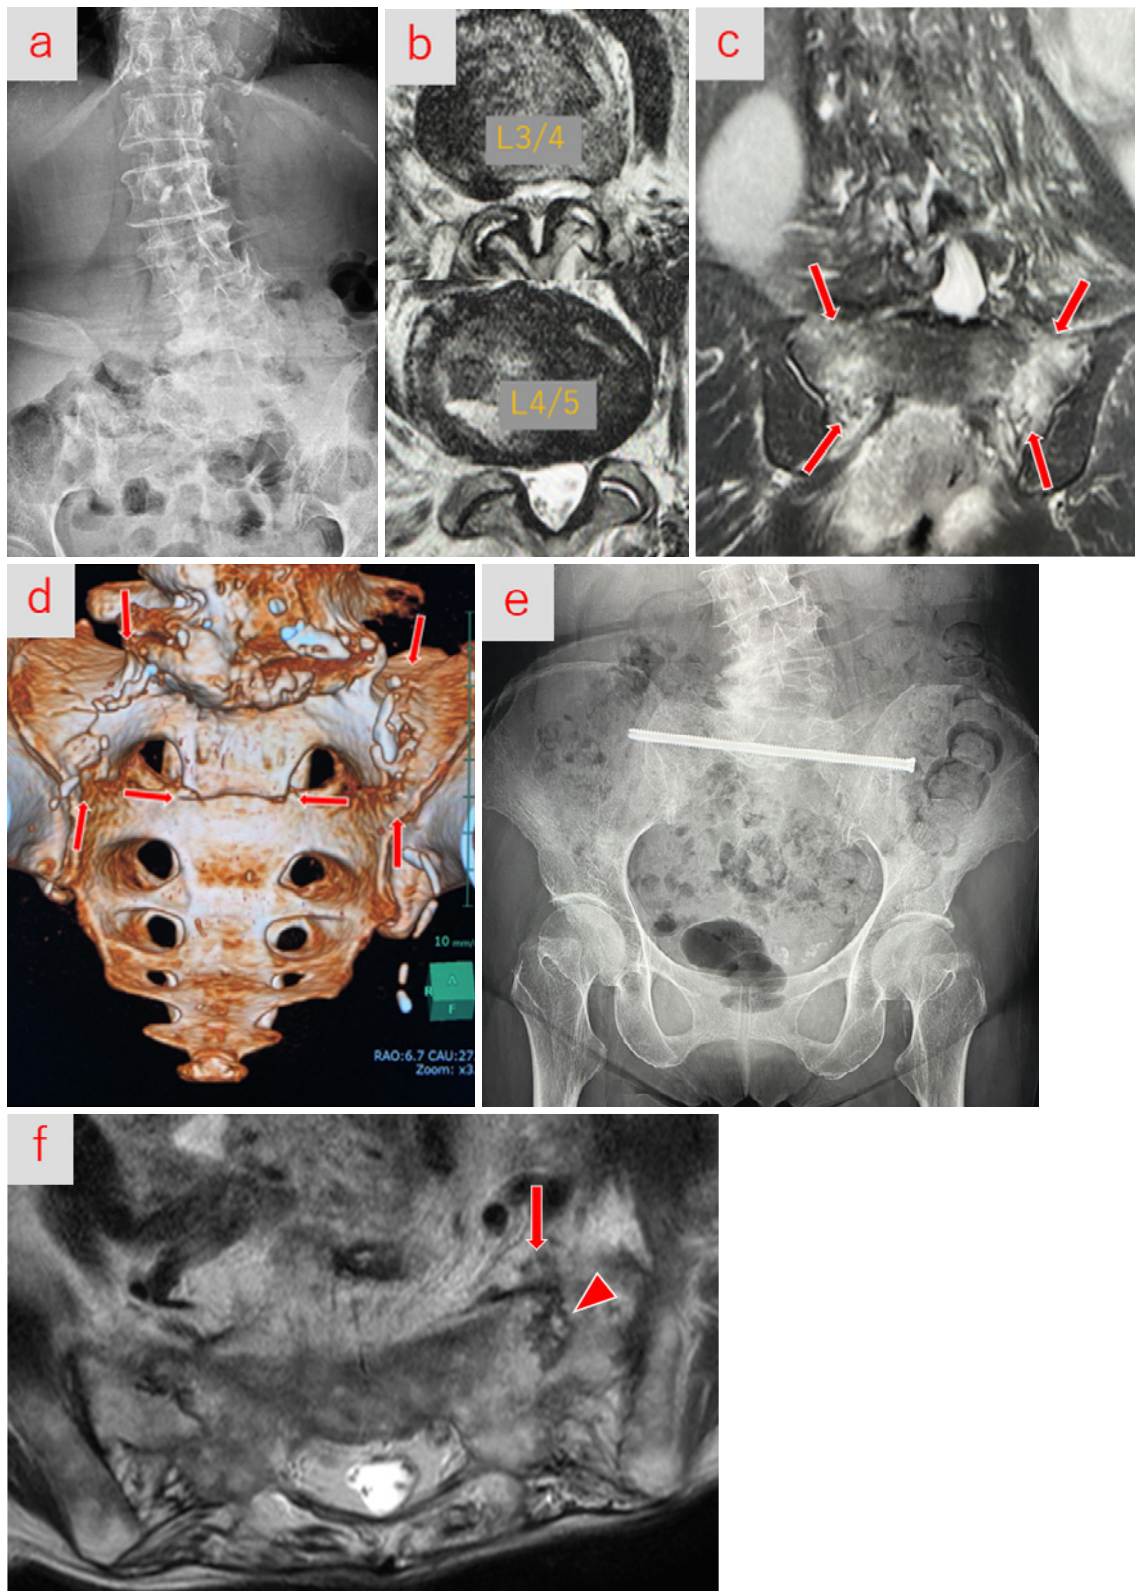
Case 2. a. Preoperative plain radiography showed severe degenerative scoliosis and suspected intervertebral foraminal stenosis. b. The magnetic resonance imaging (MRI) of the lumbar spine showed L3/4 canal stenosis. c. T2-weighted MRI showed a sacral alar insufficiency fracture (arrows). d. Computed tomography (CT) revealed a minimally displaced sacral fracture, Denis classification Zones I–III, Rommens classification Type IVb, AO classification Type C0 (arrows). e. Postoperative plain radiography after osteosynthesis using transiliac-transsacral screw (TITS). f. T2-weighted MRI showed the left L5 nerve root (arrow) was near the site of the sacral fracture (arrowhead).
